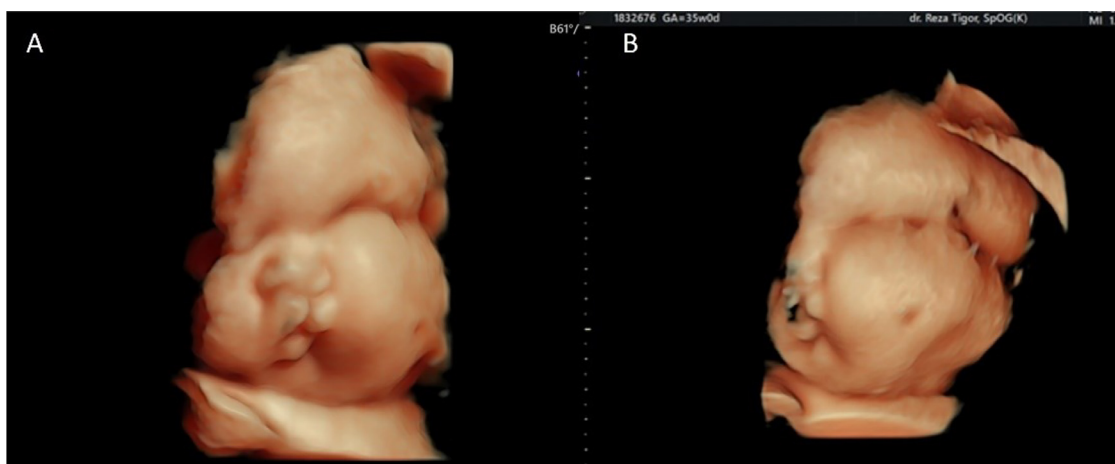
(A, B) 3D ultrasound showing a cleft palate, double lips, and malformed facial images.
